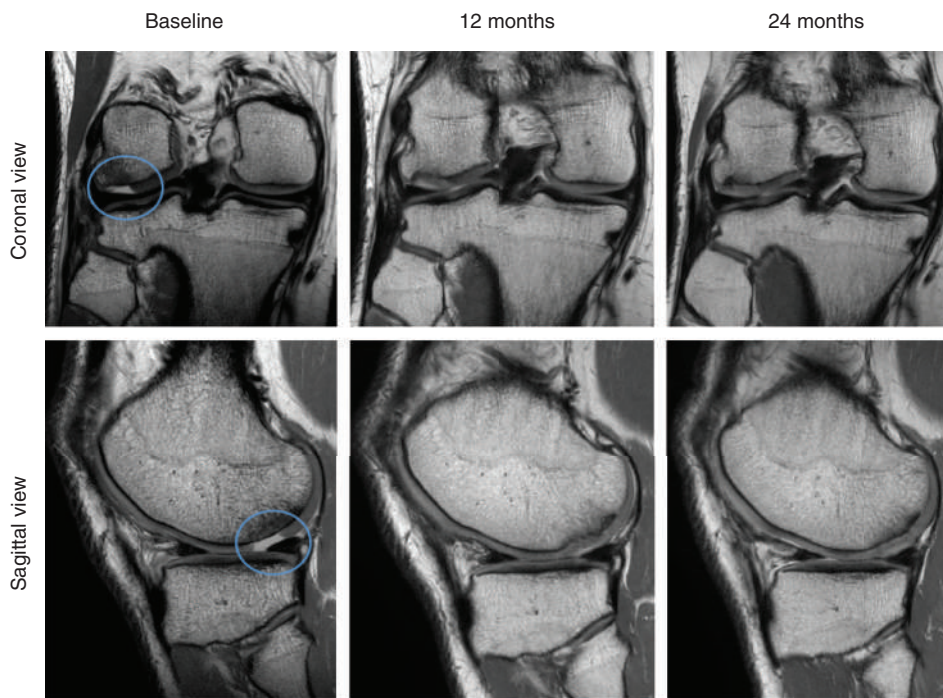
Sequential coronal and sagittal magnetic resonance imaging proton density images at baseline, 12 and 24 months of a participant. The focal chondral defect (blue circle) improves progressively over time with modified International Cartilage Repair Society score improving from Grade 1 at 12 months to Grade 0 at 24 months. Smooth integration is observed between regenerative and native cartilage.
